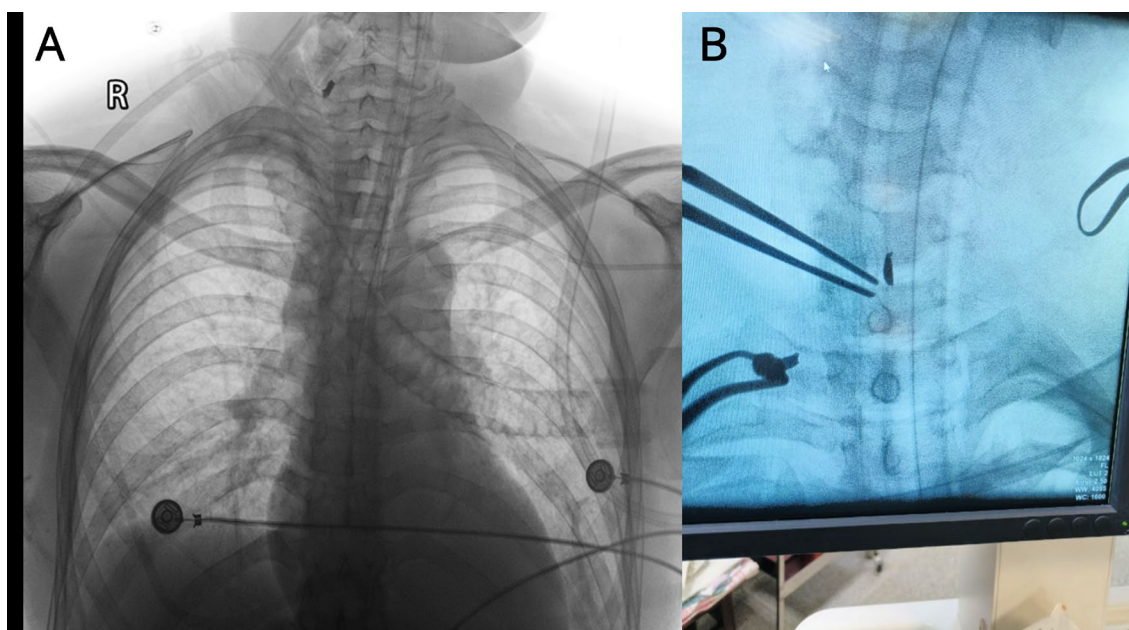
Panel A. An X-ray showing a metallic fragment projected over the right transverse process of C7. Panel B. Removal of the foreign body under fluoroscopic guidance.
